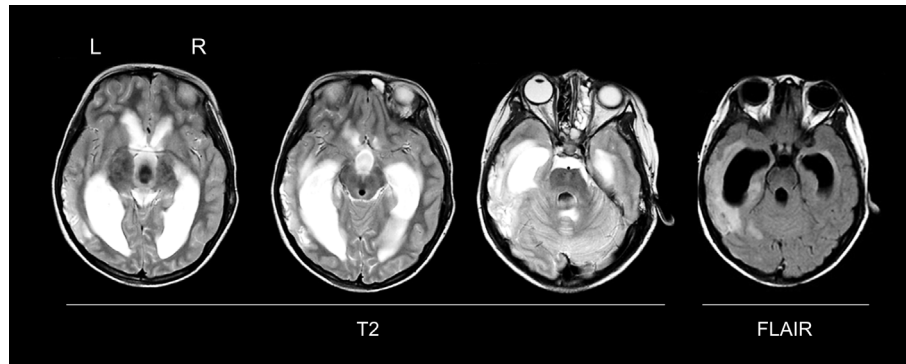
Structural magnetic resonance imaging (MRI) in the acute stage. A MRI (T2-weighted, and FLAIR sequences) was performed 4 days after traumatic brain injury, showing a marked communicating hydrocephalus with transependymal edema and a large area of contusion in the left lateral temporal lobe extending into the parahippocampal gyrus. Axial slices in native space are shown. L, left; R, right.
